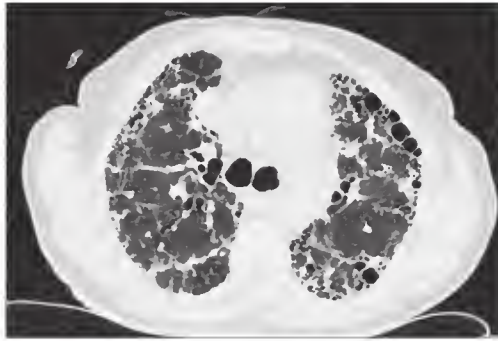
Computed tomographic scan of the chest shows the pattern associated with usual interstitial pneumonia (UIP). Note the peripheral coarse honeycomb pattern that is the hallmark of UIP.
